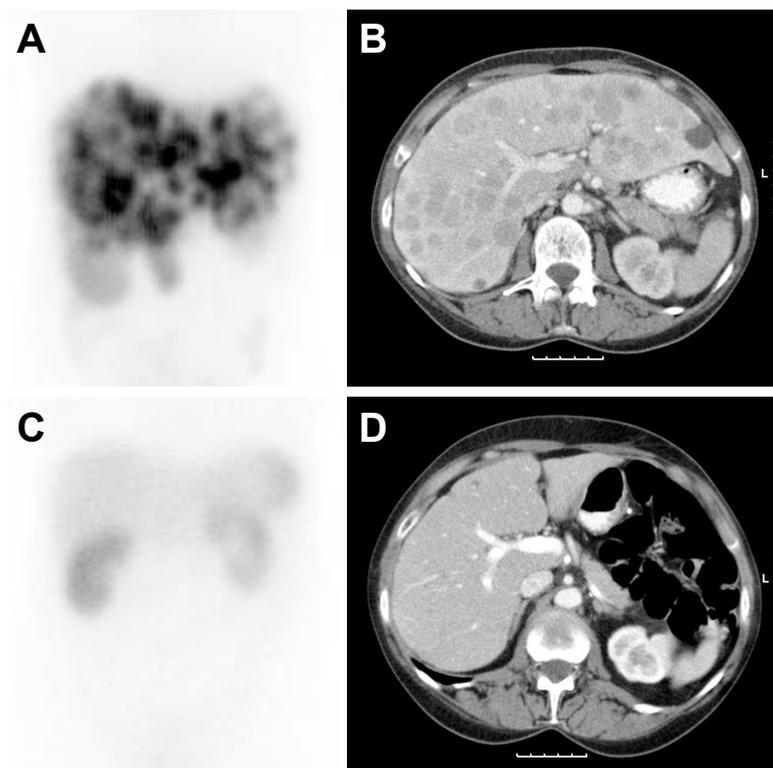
Extensive, diffuse, hepatic metastases were visualised on both (A) ^{111}In -octreotide scintigraphy and (B) a CT scan performed 1 month before initiation of treatment with ^{177}Lu -octreotate. The patient received a cumulative dose of 29.8 GBq. No abnormal uptake was seen on (C) ^{111}In -octreotide scintigraphy and (D) a few very small hypodense lesions were seen on contrast-enhanced CT scans performed 1 year after the end of treatment with ^{177}Lu -octreotate. The patient was classified as having partial remission.
